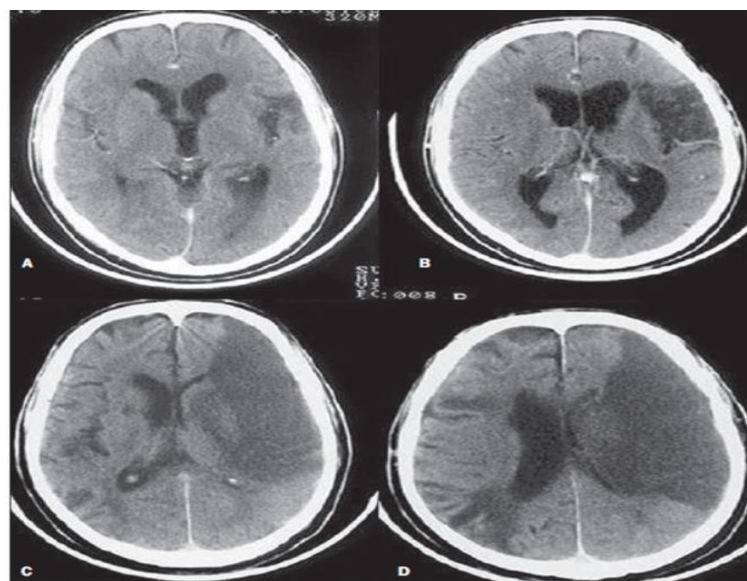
CT scan of an ischemic stroke in the MCA territory. A,B: Partial infarction, with involvement restricted to the left hemisphere. C,D: Complete infarction on the left, with mass effect compressing the lateral ventricle. Lesser left hypodensity can be seen in the right hemisphere. Source: (21).
